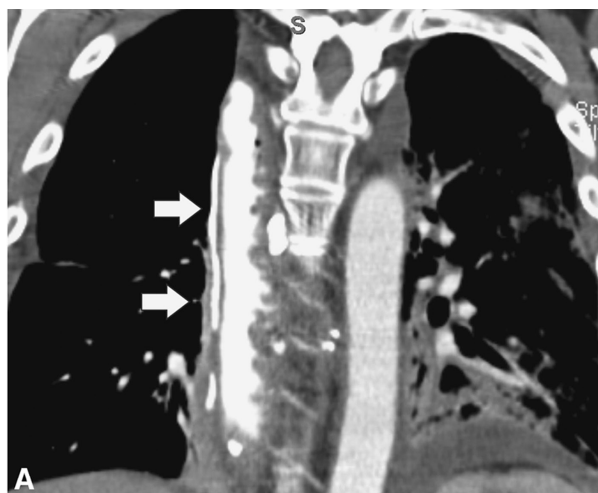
CT and esophagogram of a patient 5 weeks after Ivor-Lewis esophagectomy representative of a false-negative esophagogram. A: Coronal CT scan shows extravasation of oral contrast medium (*arrows*) confirming perforation. B: Fluoroscopic esophagogram in the same patient is without evidence of contrast extravasation or other signs of perforation and thus a false negative.
